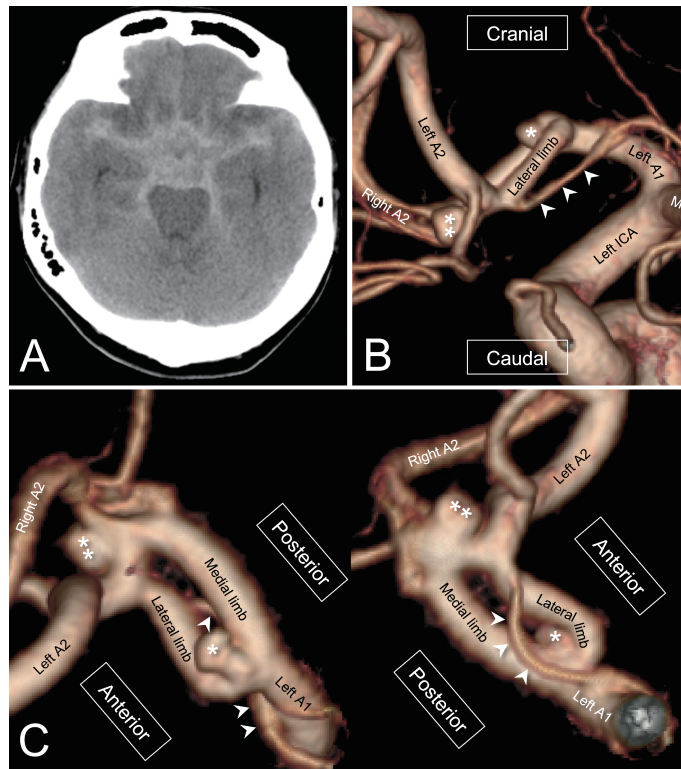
Preoperative computed tomography (CT) (A) and three-dimensional rotational angiography (3D-RA) of the left internal carotid artery injection (B, C)
